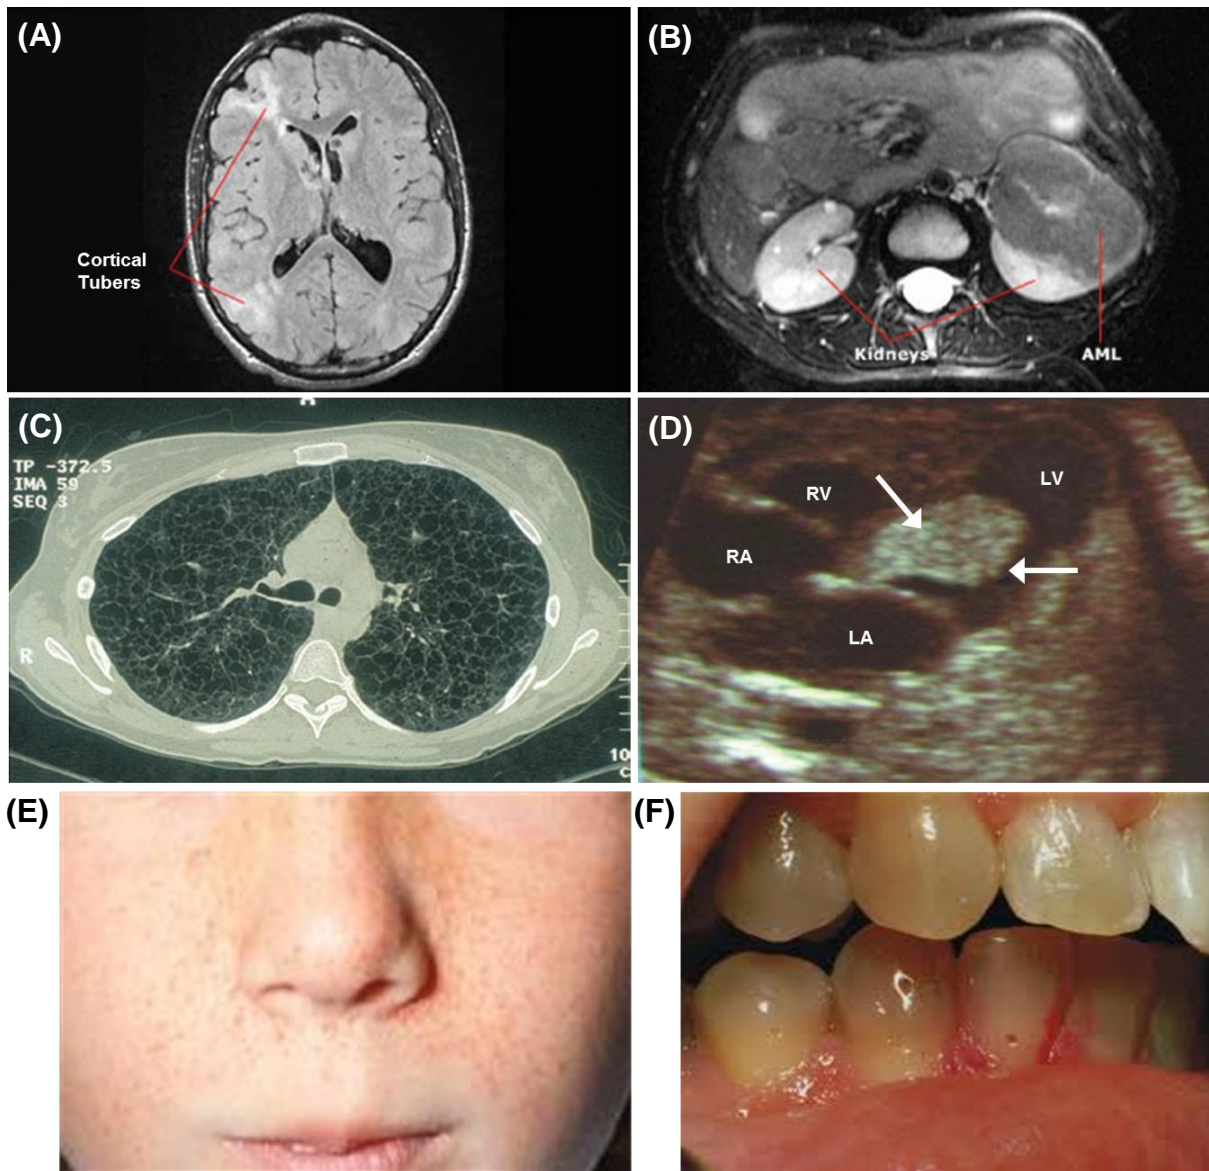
Clinical features of TSC. (A) Axial brain MRI showing cortical tubers. (B) MRI showing renal angiomyolipoma. (C) High resolution chest CT showing the lungs of an individual with TSC who has lymphangiomyomatosis. (D) Fetal echocardiogram showing a cardiac rhabdomyoma (arrows in the left ventricle of the heart of a fetus with TSC). LV, left ventricle; RV, right ventricle; LA, left atrium; RA, right atrium. (E) Typical distribution of angiofibromas. (F) Dental pits.
